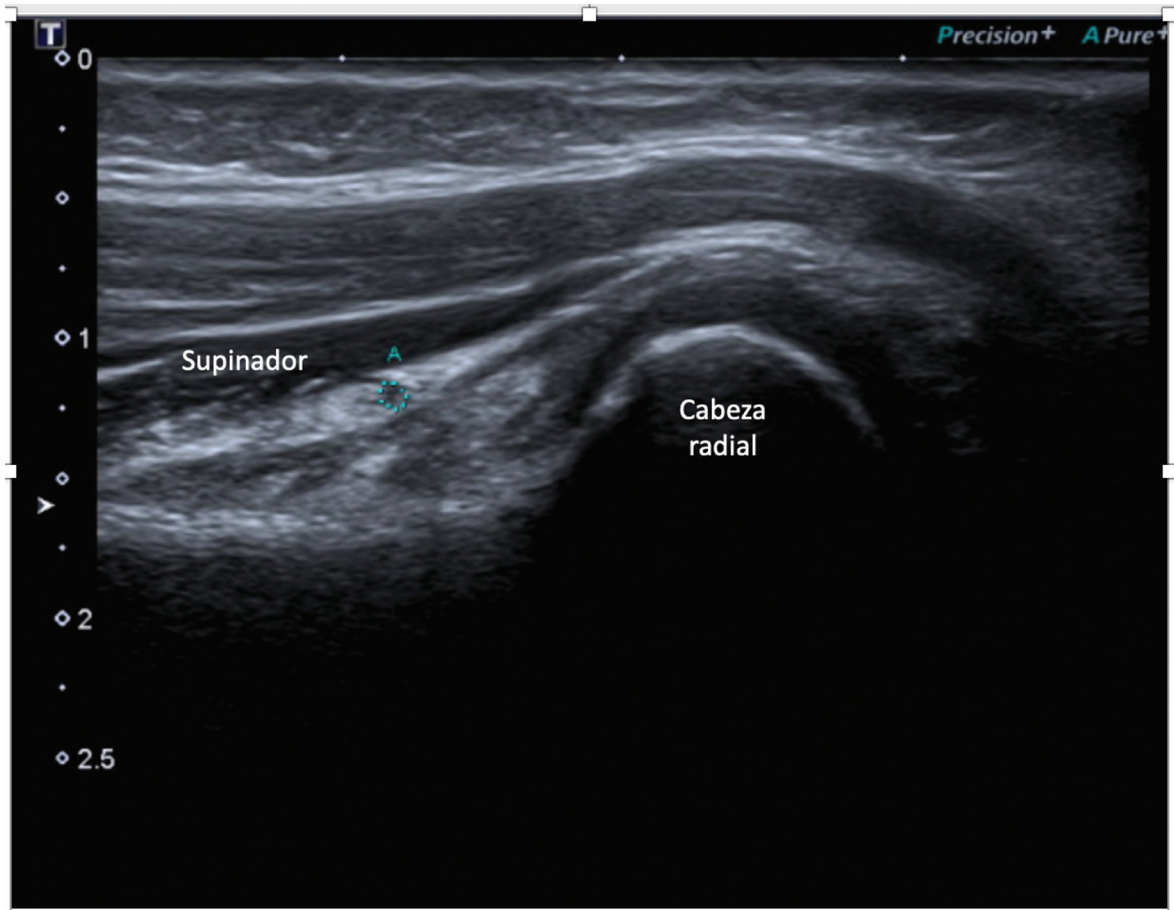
Ultrasound image showing the decreased nerve diameter over the supinator arch.
